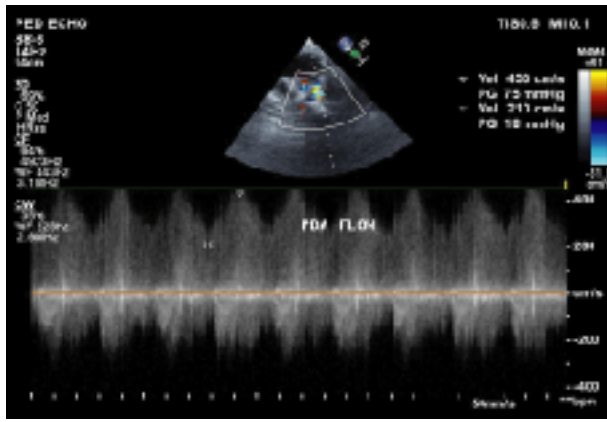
Doppler Echocardiography shows PDA flow.
